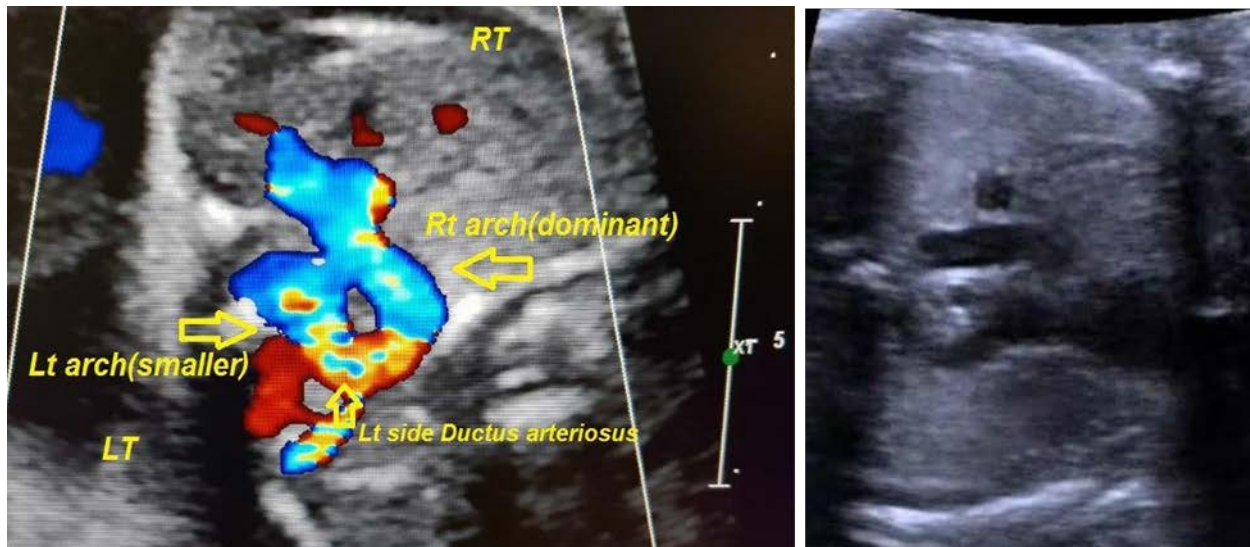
Left) The axial view shows a double aortic arch with a right-side dominant arch, a small left side arch, and a left side ductus arteriosus. Right) The same view in 2D echocardiography.
